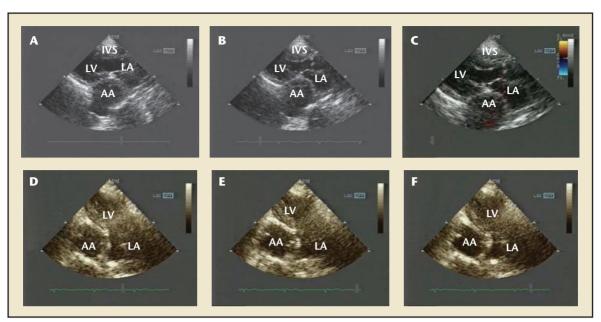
Transthoracic echocardiogram. Parasternal views show the aneurysm compressing the LA and LV (A-C). Apical 2-chamber views show the thoracic aneurysm (D-F). IVS, interventricular septum; LV, left ventricle; LA, left atrium; AA, ascending aorta.
